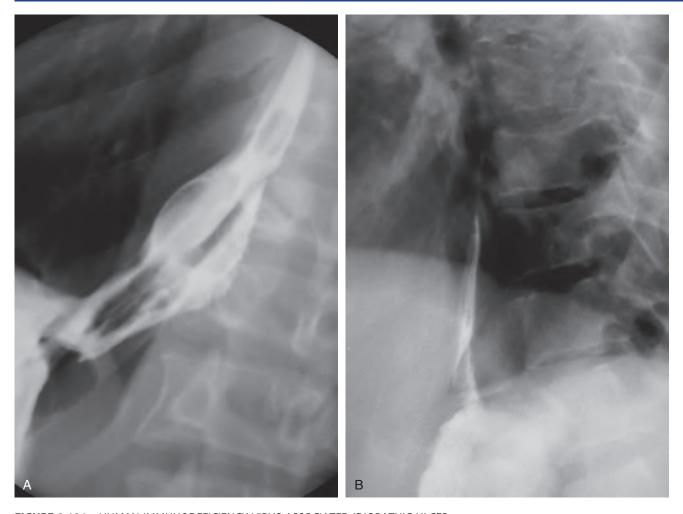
HUMAN IMMUNODEFICIENCY VIRUS-ASSOCIATED IDIOPATHIC ULCER A, Marked abnormality of the gastroesophageal junction, suggestive of ulceration. B, Barium is refluxing into the more proximal esophagus. The combination of these two radiographic findings suggests reflux disease.
